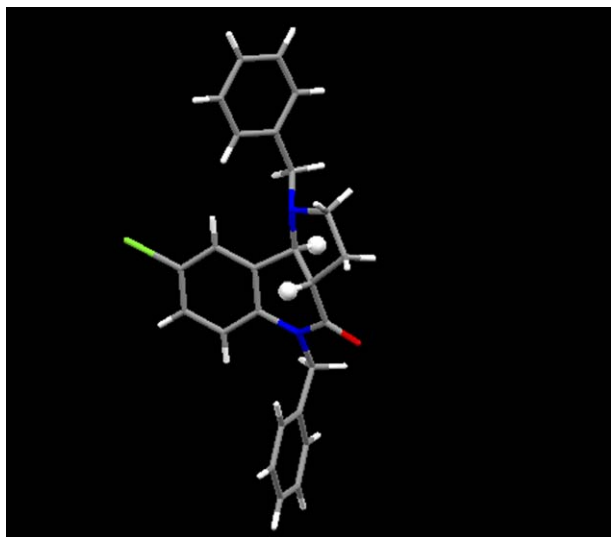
X-ray structure of *trans*-26 (bridge head hydrogens picked out for emphasis).
